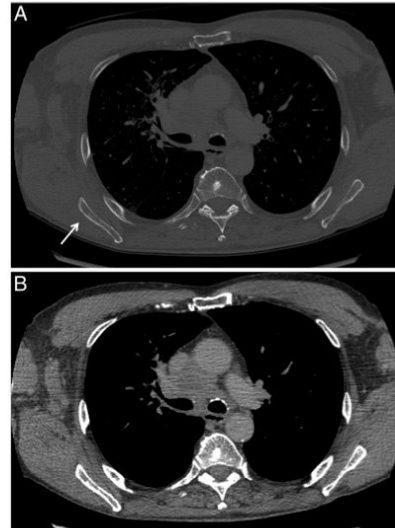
CT contrast-enhanced image reformatted using 1.25 mm axial thickness for (A) a bone reconstruction showing that the bone metastasis visible on ¹⁸F-misonidazole (FMISO) positron emission tomography (PET) is not visible on CT and (B) standard reconstruction showing the enlarged mediastinal nodal disease shown to be hypoxic on the FMISO PET.
